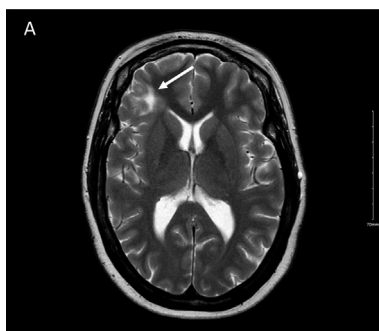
Pre-Op MRI (Axial FSE T2W) Right Fronto -lateral dysplasia(arrow).
